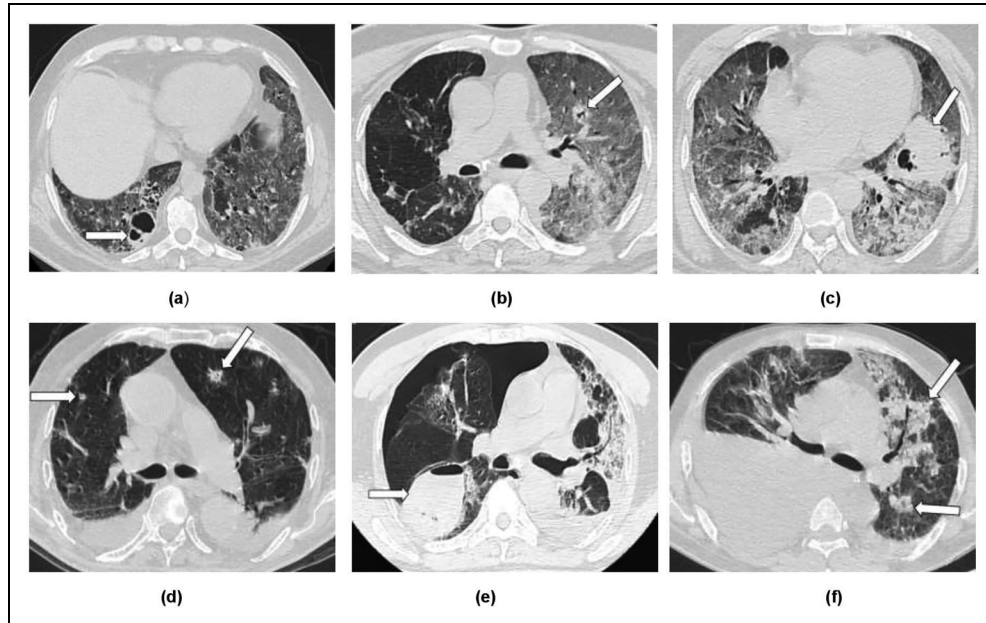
Representative patterns of chest CT of CAPA patients observed at our institute. (a) multiple small nodules with presence of cavitation in left lung nodule, (b) small nodular lesion left upper lobe with presence of cavitation, (c) consolidation in lingular segment with cavitory changes, (d) cavitory lesion, (e) rounded abscess with air fluid level with presence of pneumothorax, and (f) multiple poorly margined nodular lesions coalescing to form a consolidation patch. The arrows show the case-specific lung lesions. Abbreviations: CT, computed tomography; CAPA, COVID-19 associated pulmonary aspergillosis.
